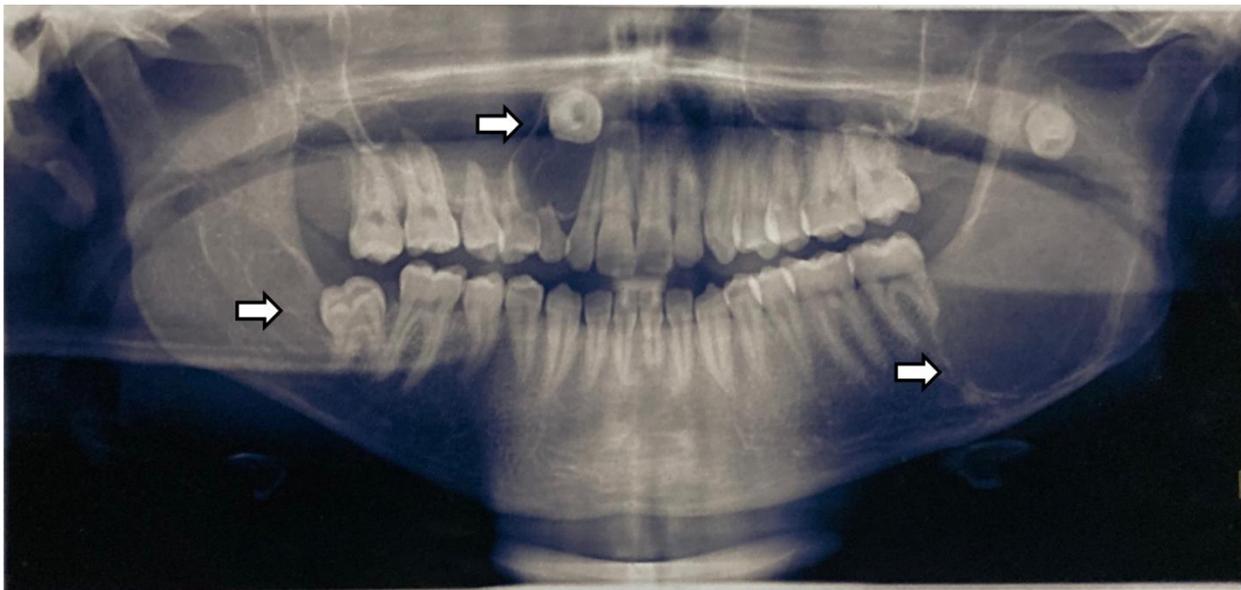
Orthopantomogram depicting multiple OKC's in relation to impacted 13,38 and distal to 37.
